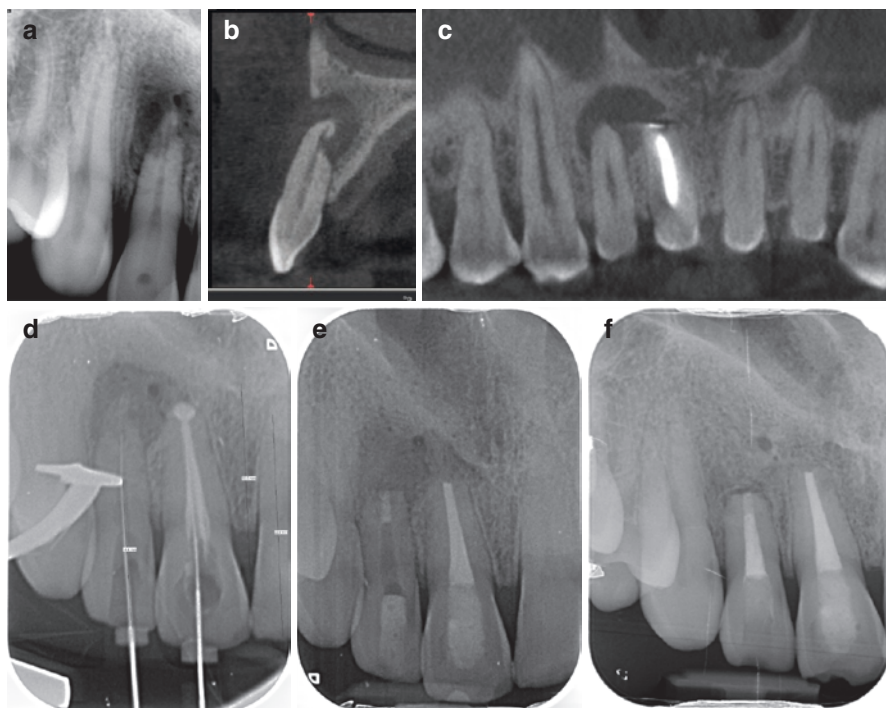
Clinical case of periapical lesion involving central and lateral right maxillary incisors. Radicular root resorption is detectable on periapical radiograph; however it does not really help for managing the case (a). On the CBCT, the location of the resorption is visible on the palatal site of the apex of the right lateral maxillary incisor (b, c). This case had been treated with a combined approach. First, orthograde retreatment of the right maxillary central incisor and initial treatment of the right lateral maxillary incisor were performed (d). Then, periapical surgery was done in order to manage surgically the external root resorption (e). Healing is complete around the apices, and a residual connective tissue can be seen 4 years after surgery (f)
